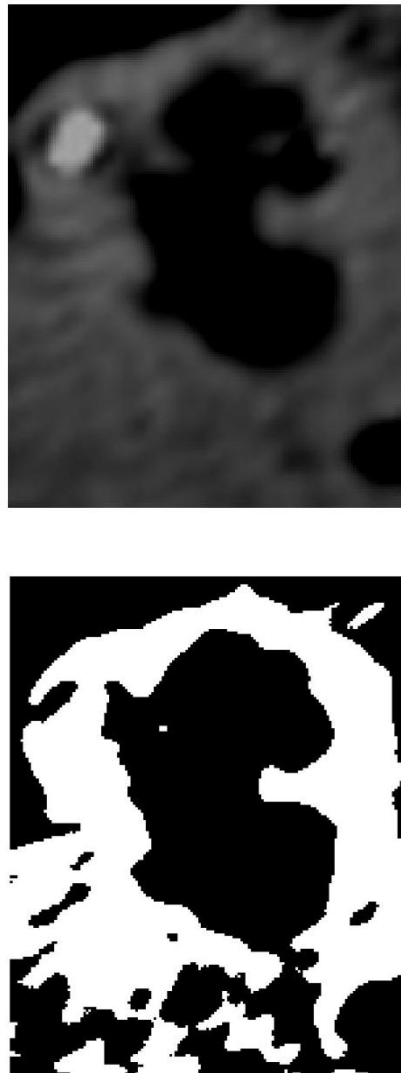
Through the combination of contrast enhanced images the combined binary image (bottom) is derived from the CT scan (top).
